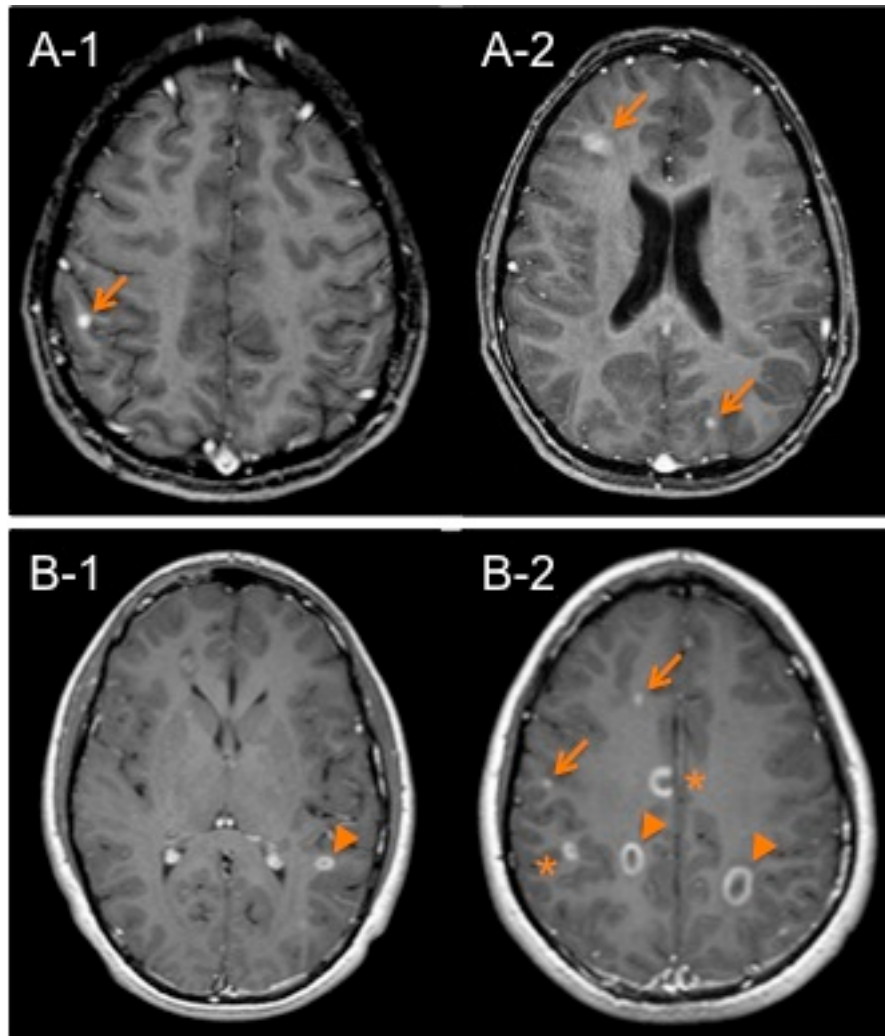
Axial post-gadolinium T1-weighted images from two children with MS (panels A and B). Focal enhancing lesions are depicted by arrows in A-1, A-2 and B-2. Closed ring-like enhancing lesions are denoted by arrowheads in B-1 and B-2, and open ring-like enhancing lesions by asterisks in B-2.
